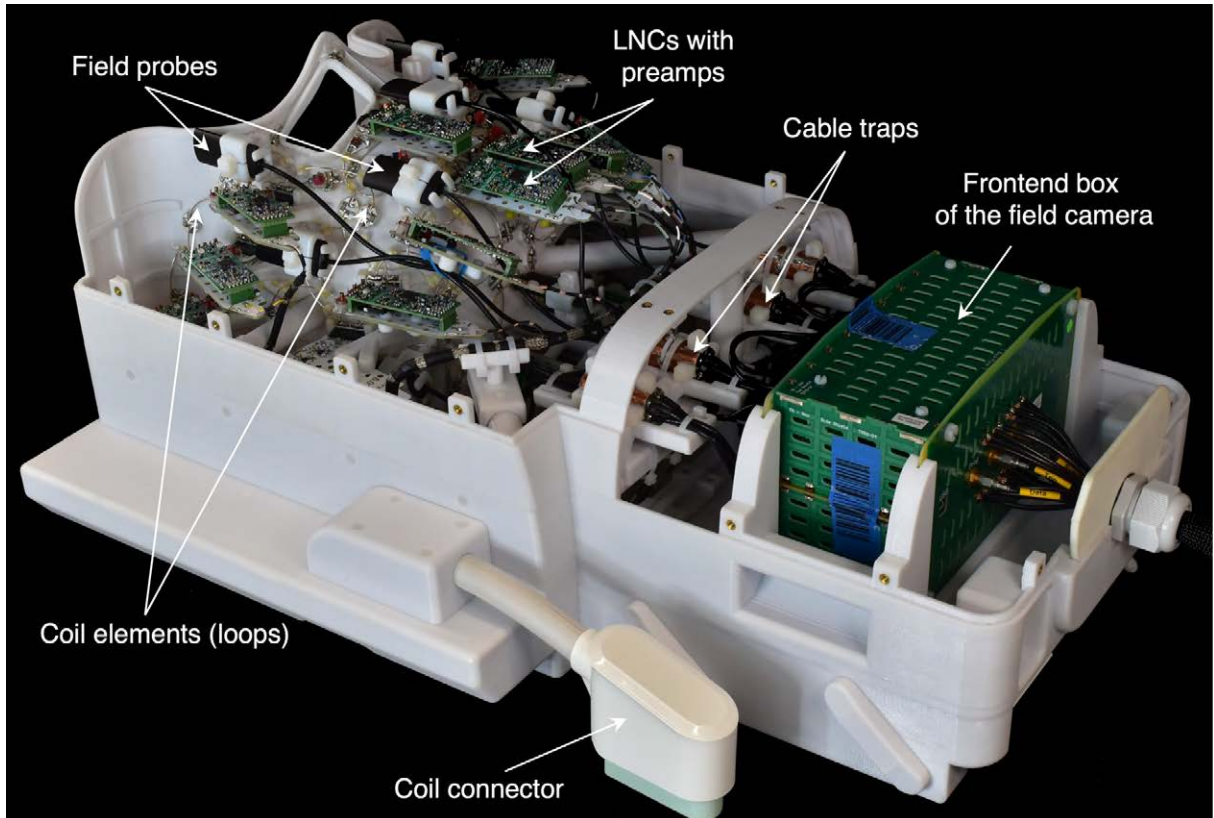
Custom-built 64-channel receive array for MRI of the human head at 3 T with 16 integrated probes for dynamic magnetic field monitoring. The coil was designed and built by Boris Keil and Mirsad Mahmutovic at Mittelhessen University of Applied Sciences, Giessen, Germany.
